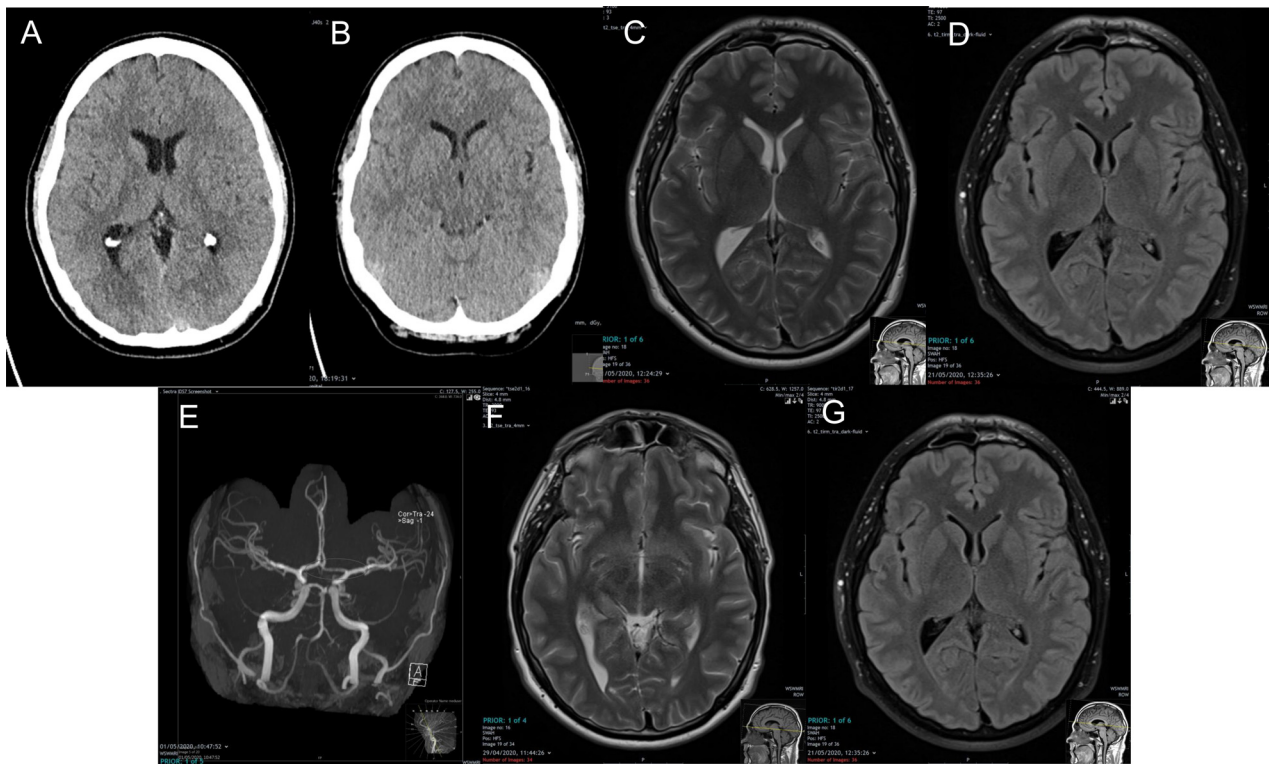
A) Day 1 CT Brain – Normal; B) Day 2 CT Brain– Normal, standard 24-hour post thrombolysis imaging; Day 3 MRI Head T2 (C) and FLAIR (D) – Normal; E) Day 5 MRA Head - normal with congenitally hypoplastic left A1 segment anterior cerebral artery- marked on image (incidental finding) (TOF image); F) Day 25 MRI Head T2 (F) and FLAIR (G) –Normal.
